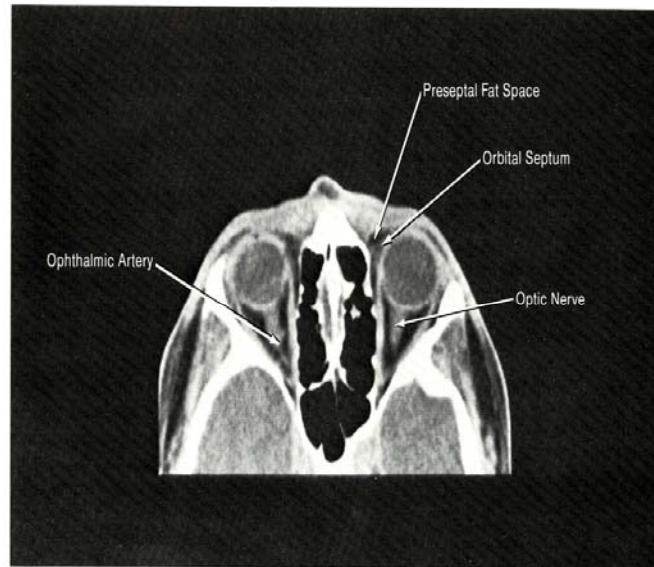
Axial CT defining preseptal space.
